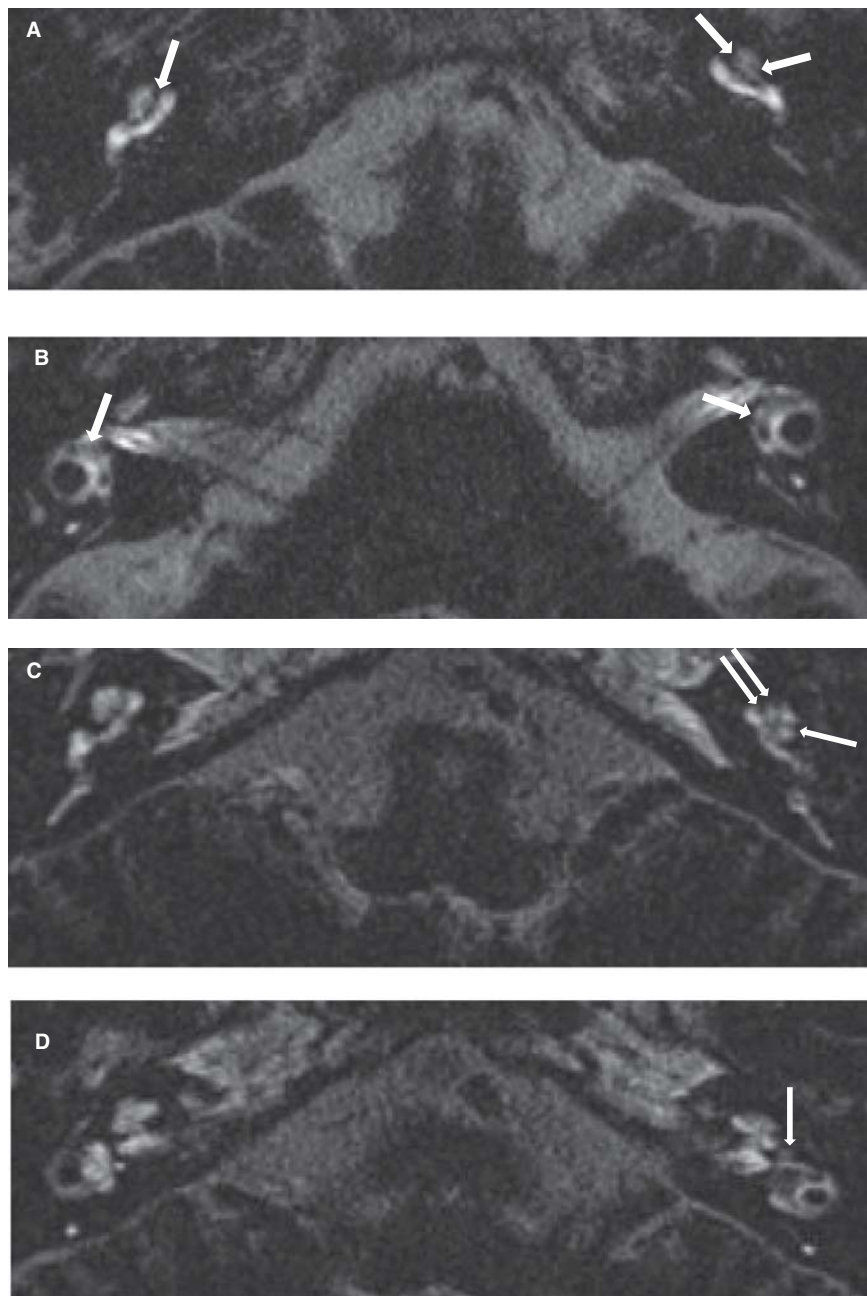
hT(2)W-3D-FLAIR MRI taken 4 h after intravenous double-dose (A, B) and standard-dose (C, D) Gd injection. (A, B) A 64-year-old female patient with bilateral Meniere's disease. (A) Endolymphatic hydrops was recognized in the cochlea of both ears (arrows). (B) Significant endolymphatic hydrops was recognized in the vestibules of both ears (arrows). (C, D) A 43-year-old male patient with unilateral Meniere's disease in the left ear. (C) Significant endolymphatic hydrops was recognized in the left cochlea. (D) Significant endolymphatic hydrops was recognized in the left vestibule (arrow).
